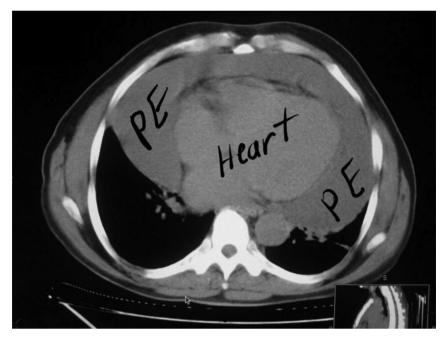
Computed tomography of chest shows massive pericardial effusion.
